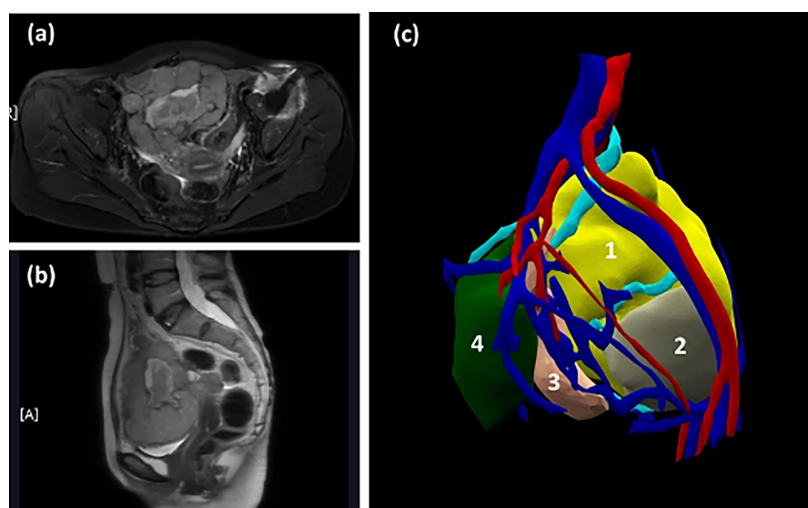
(a) Transverse section of MRI; (b) Sagittal section of MRI; (c) 3D reconstruction of MRI
